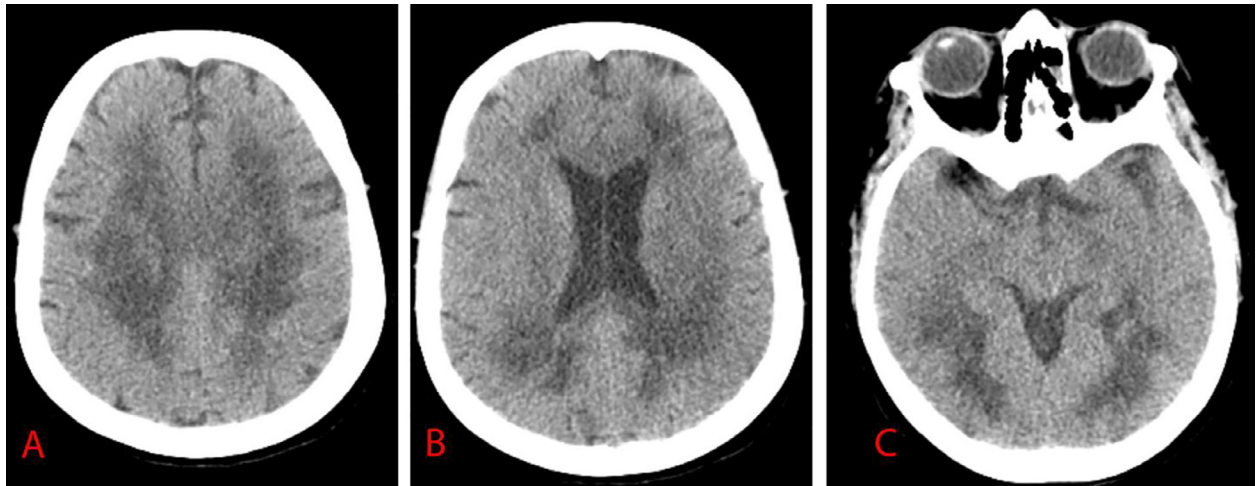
CT scan of brain (second patient) (). Three days after previous MRI. (A-C) Axial CT brain reveal diffuse white matter hypodensity sparing cortical grey matter.
